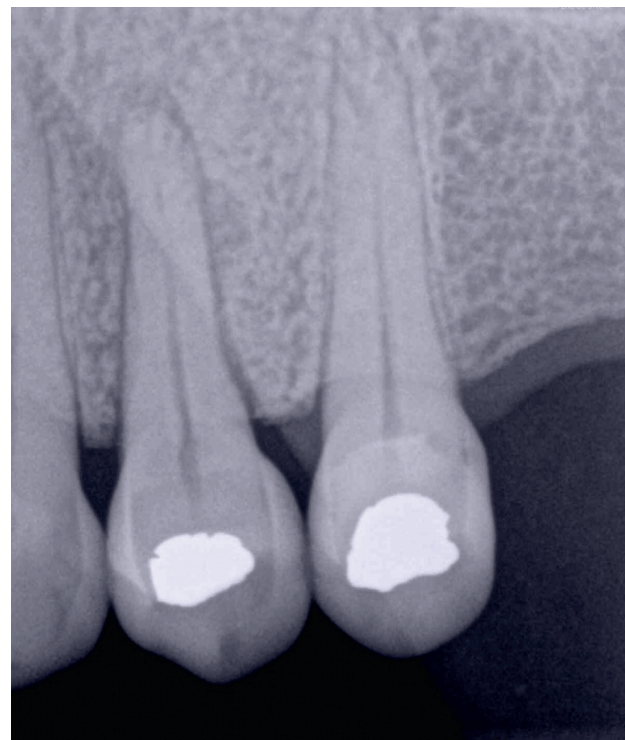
Initial x-ray - note the periapical areas shown.
